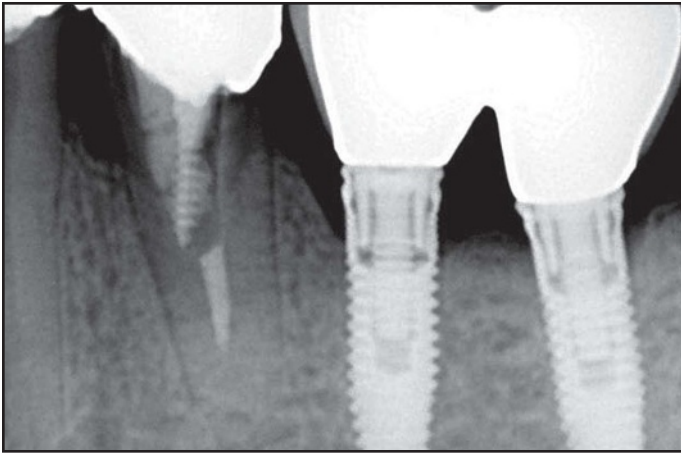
Radiograph of fractured tooth 20.
